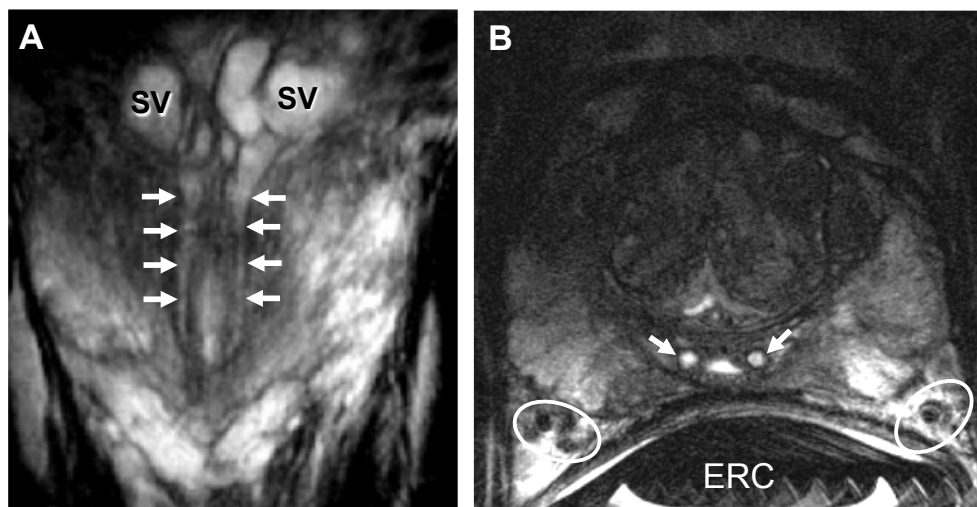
MR images of a 53-year-old patient (PSA level 3.74 ng/ml, normal digital rectal examination) depicting the anatomy of the prostate related to locoregional spread. (A) The seminal vesicles (SV) are cranially located on the base of the prostate and the ejaculatory ducts (arrows) drain into the verumontanum. (B) The neurovascular bundle (NVB) (white circles) is situated parasagittally to the dorsolateral part of the peripheral zone of the prostate. From the NVB, vessels sprout towards the prostate. *Abbreviations:* ERC: endorectal coil.
